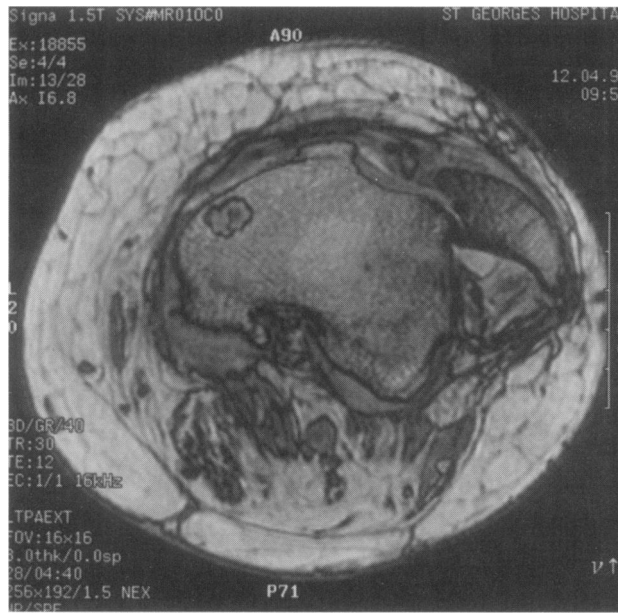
MRI scan showing bone bruising and medial retinacular injury.
